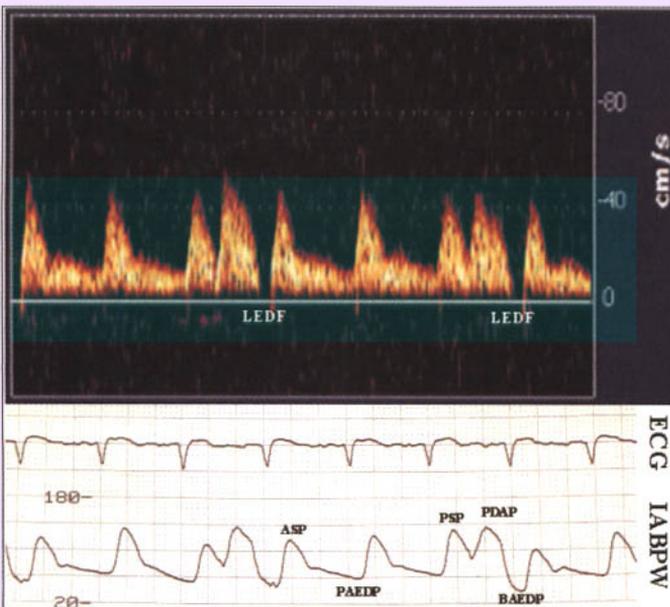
Intra-aortic balloon pump waveform (IABPW) and the middle cerebral artery velocity changes with early balloon deflation. Key to IABP waveform: ASP, assisted systolic pressure; PAEDP, patient aortic end-diastolic pressure; PSP, peak systolic pressure (unassisted); PDAP, peak diastolic augmented pressure; BAEDP, balloon aortic end-diastolic pressure; LEDF, loss of end-diastolic flow in the MCA detected by transcranial Doppler (TCD) related to early balloon deflation.
